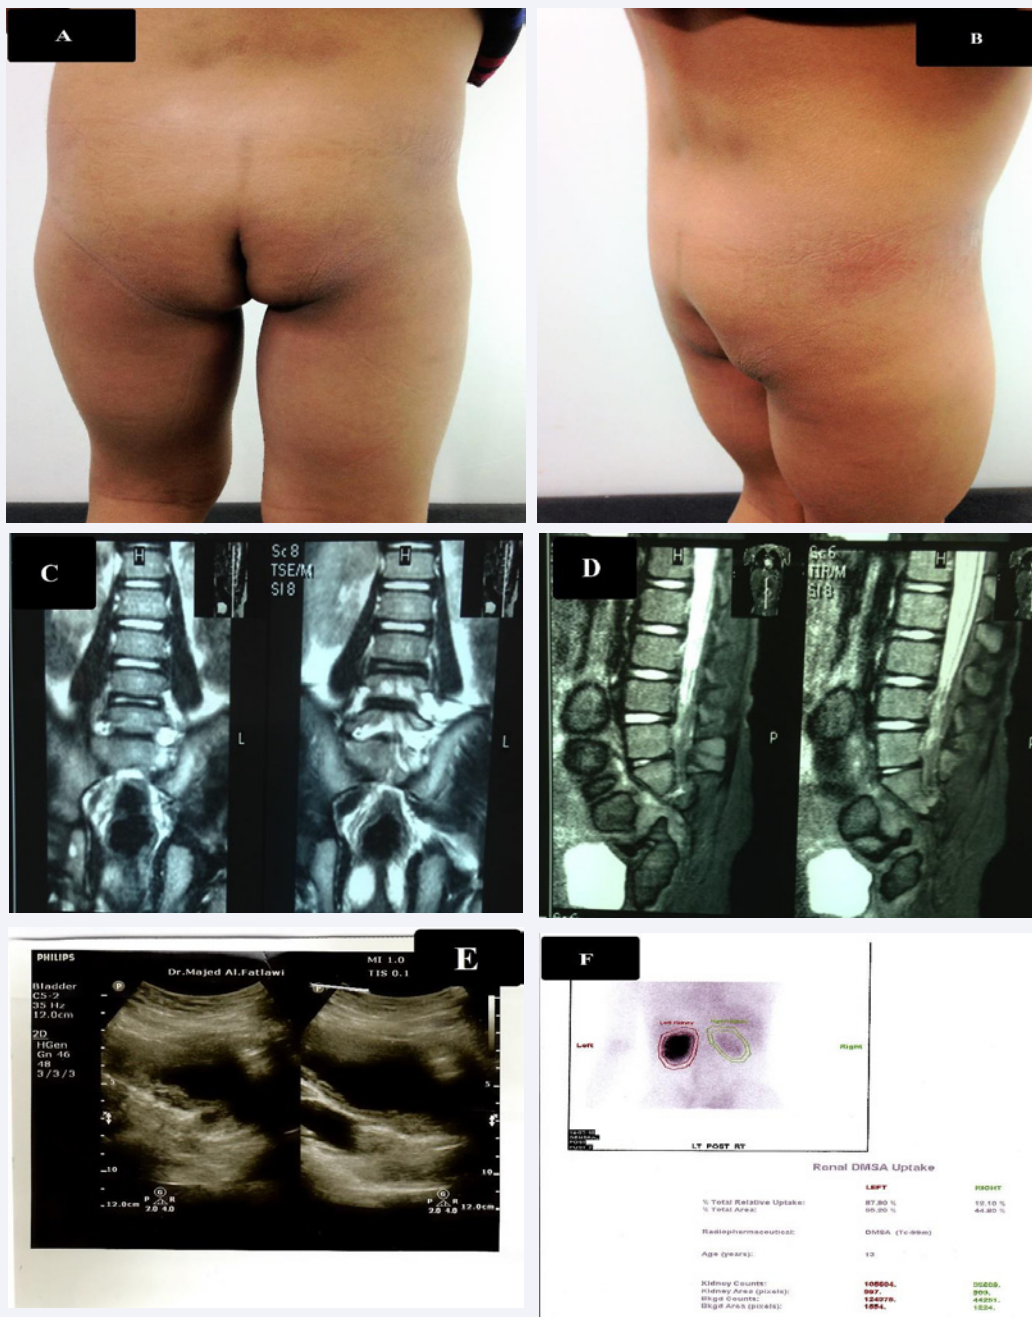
A, B, C, D, E and F; A&B: flat buttocks, and a dimple over the sacral area. C&D: MRI study revealed evidence of absent 2-5 sacral vertebrae and the coccyges (Renshaw type 2). Conus ends cephalic to the lower border of L1-2 vertebrae, and sacral deficit is large ending above S1 vertebrae. E: Ultrasonography reported thick wall with irregular trabeculated mucous membrane suggested neurogenic bladder). F: Diuretic Reno gram (135MBq Tc-99m MAG3) submitted poor function of right kidney, split function was 12%.
